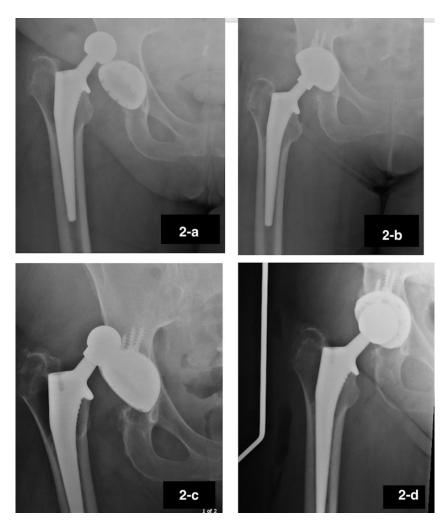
2-a Pre-op X-ray of patient with recurrent dislocation of right hip. 2-b X-ray of the same patient following revision surgery with dual mobility cup. Skirted head was used. 2-c X-ray showing dislocation following revision with the dual mobility cup. 2-d X-ray showing re-revision with constrained liner.
